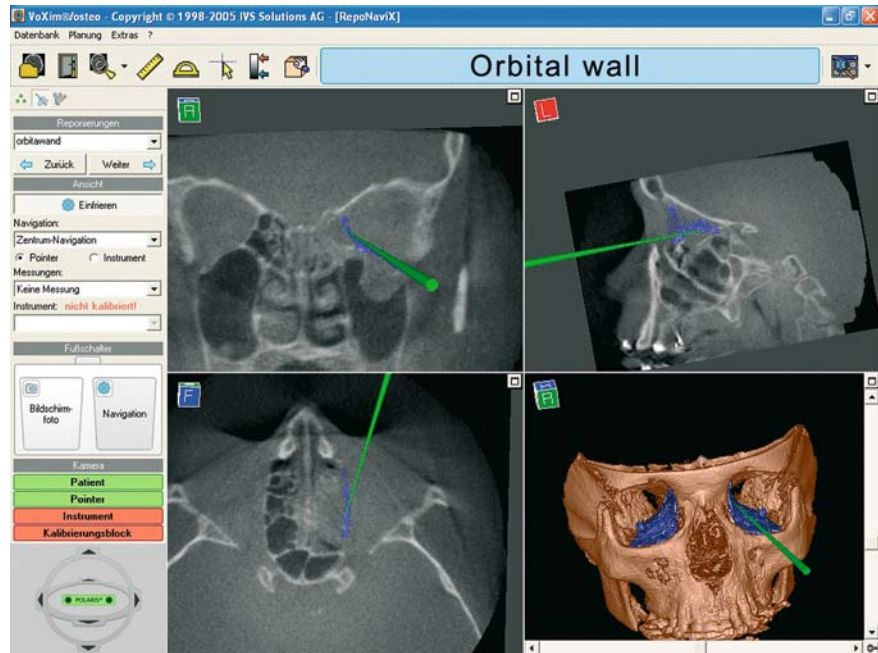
Posttraumatic primary reconstruction of the orbit – creating the virtual template on the base of a Cone Beam CT scan. The unaffected side is reflected onto the affected side, followed by segmentation and alignment to create a virtual surgical template for the orbital reconstruction (*blue segmentation*)
